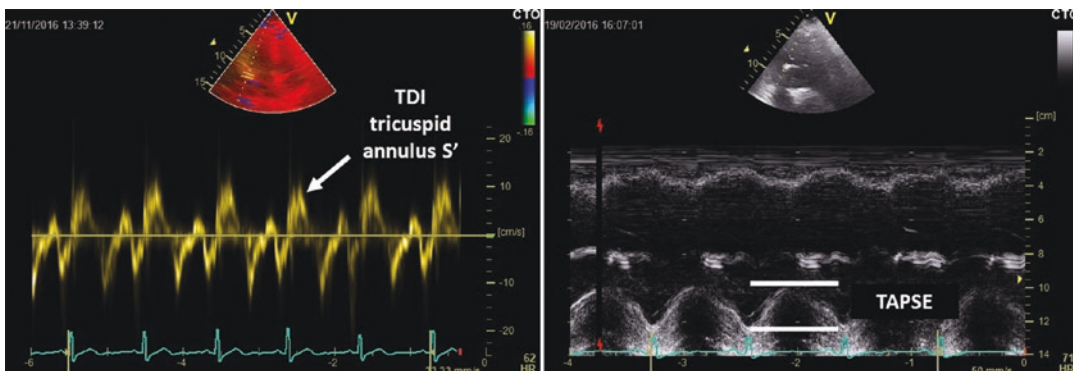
Right ventricular systolic function. Left: tricuspid annulus systolic velocity *S'* using Tissue Doppler imaging (TDI); Right: tricuspid annular plane systolic excursion (TAPSE)
